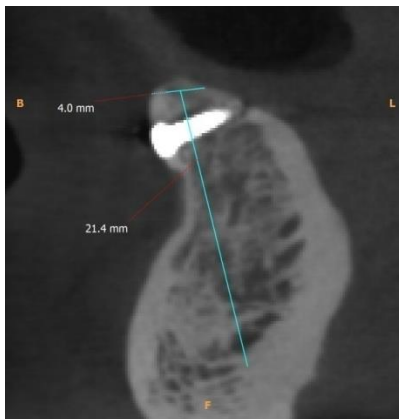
post-operative radiograph (cbct)
